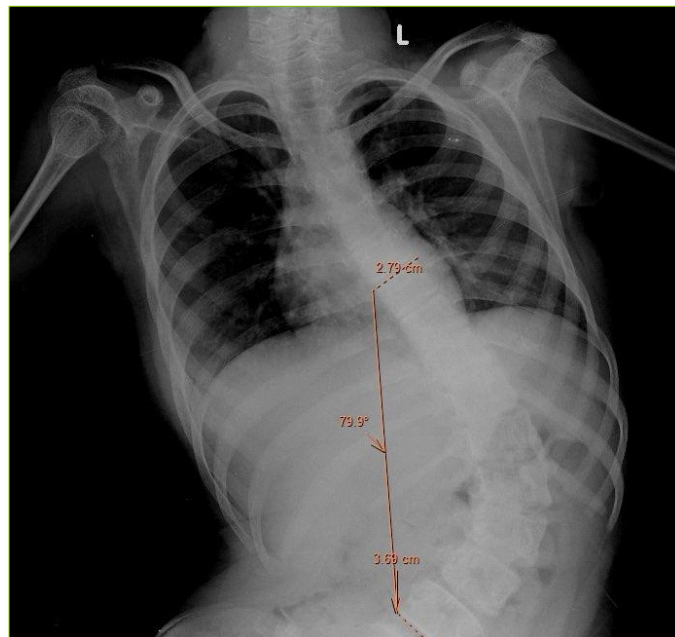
Xray with levoscoliotic curve with Cobbs angle measurement.
